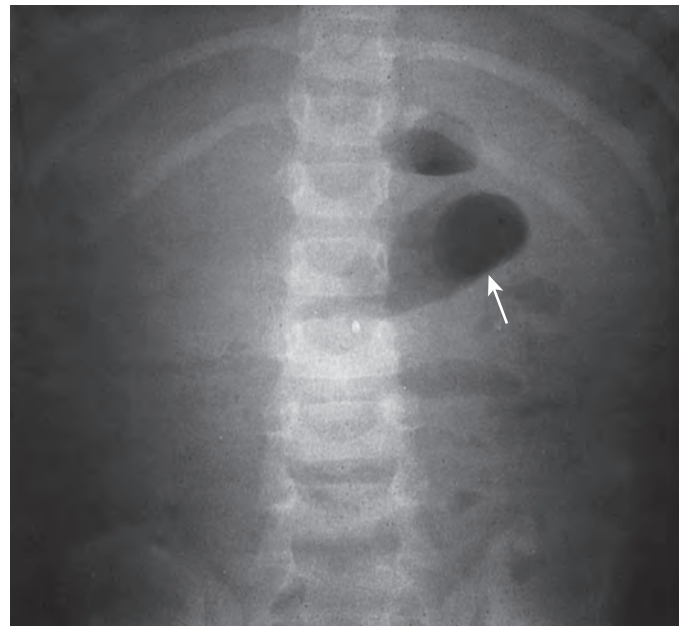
Sentinel loop. The anteroposterior radiograph shows focal dilation of a small bowel loop in the left upper abdomen (arrow), representing a localized ileus caused by peripancreatic inflammation in a 2-year-old boy with abusive traumatic pancreatitis.
